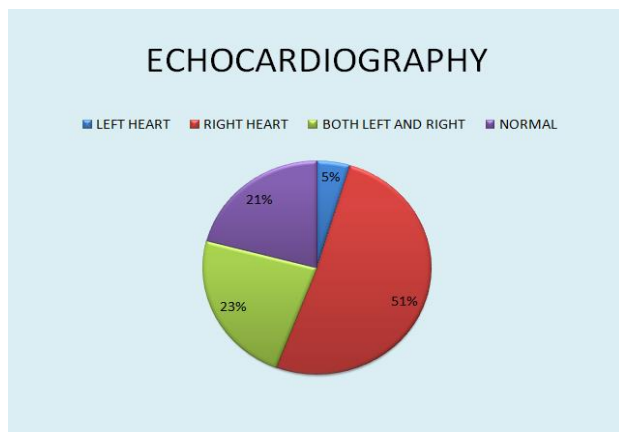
2D echocardiographic patterns of involvement in patients with severe COVID-19 pneumonia.
